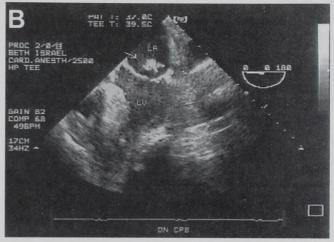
Transesophageal echocardiography image of case 3. The small protruding thrombus (arrow) appears to be organized and sits in the apex of the left ventricle. LV = left ventricle; LA = left atrium.
